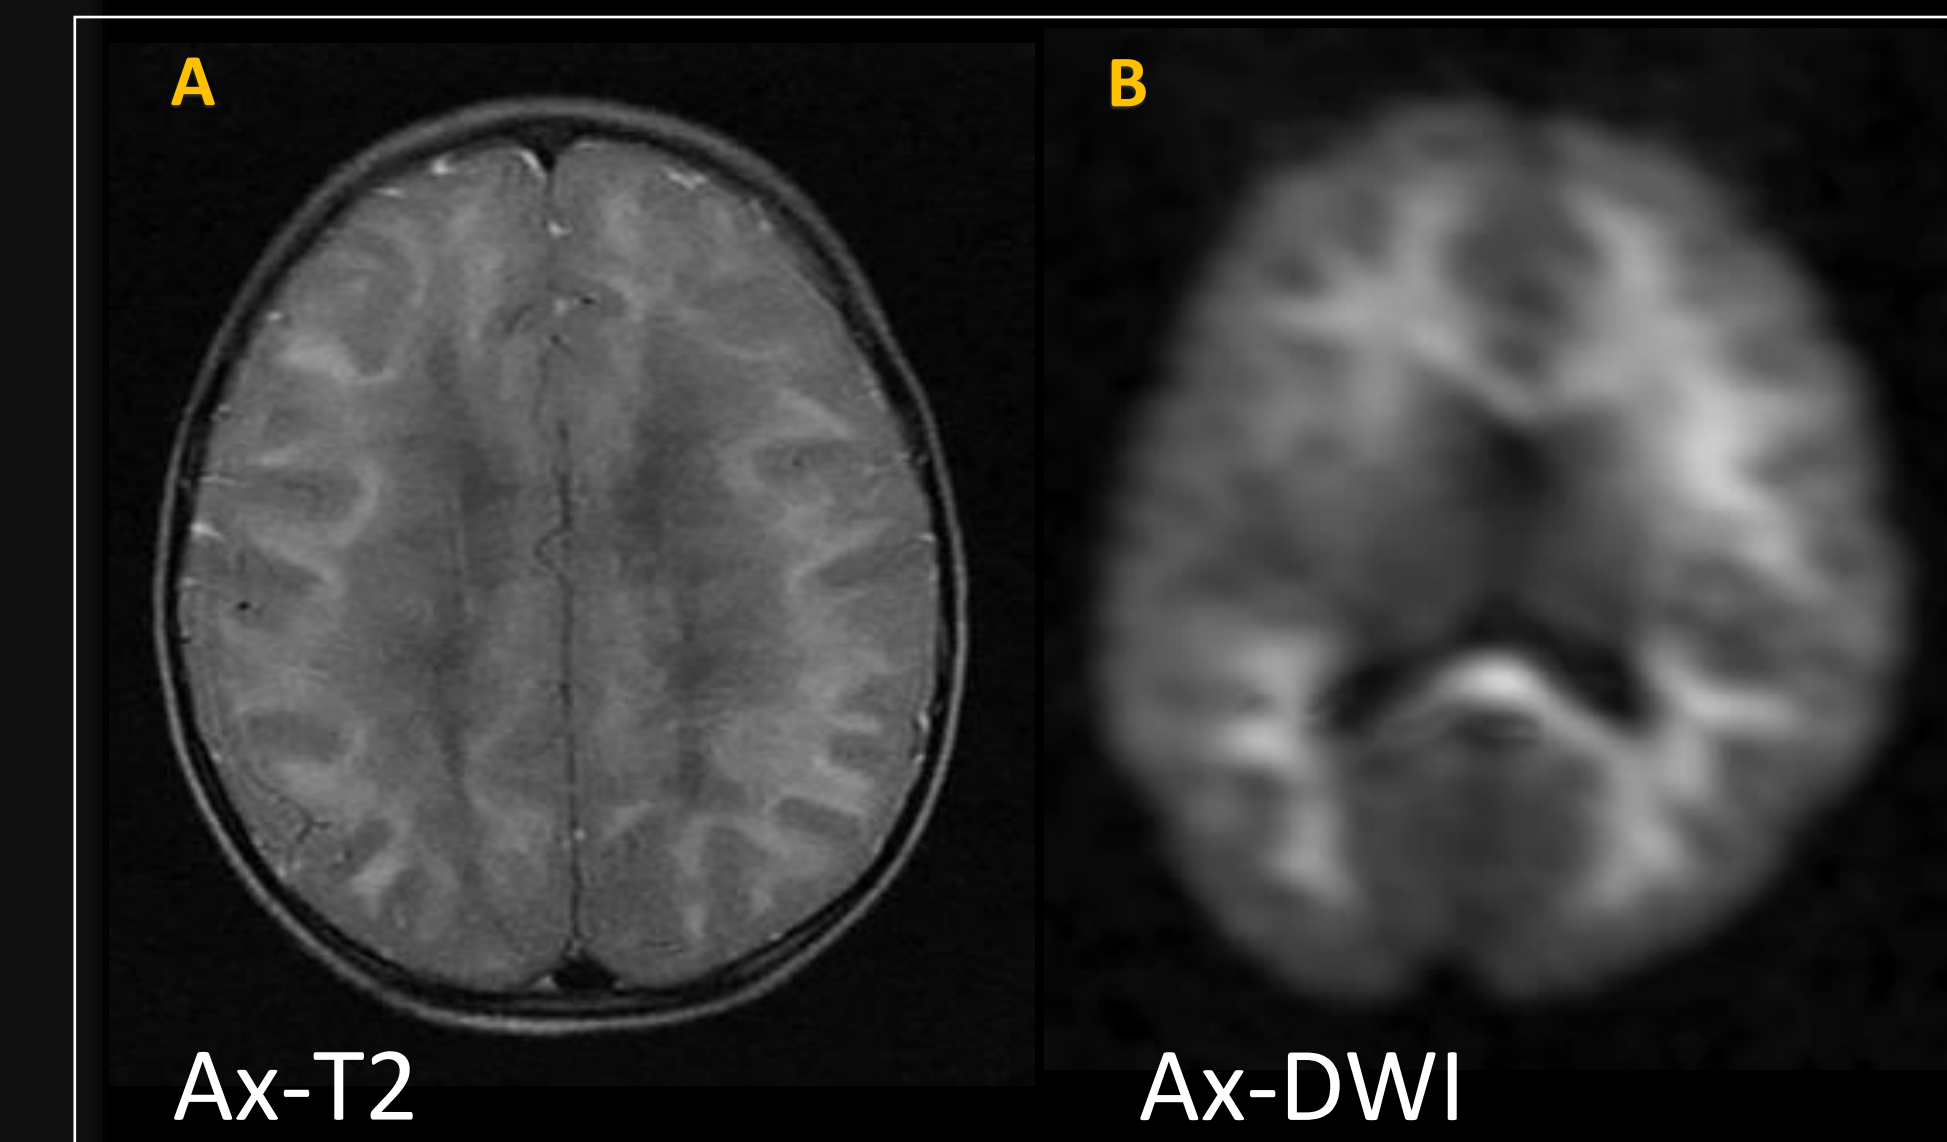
Axial images (A) through the centrum semi-ovale (T2W) and (B) lateral ventricles (DWI) demonstrating increased signal in the central and subcortical white matter, and central aspect of the splenium of the corpus callosum.
